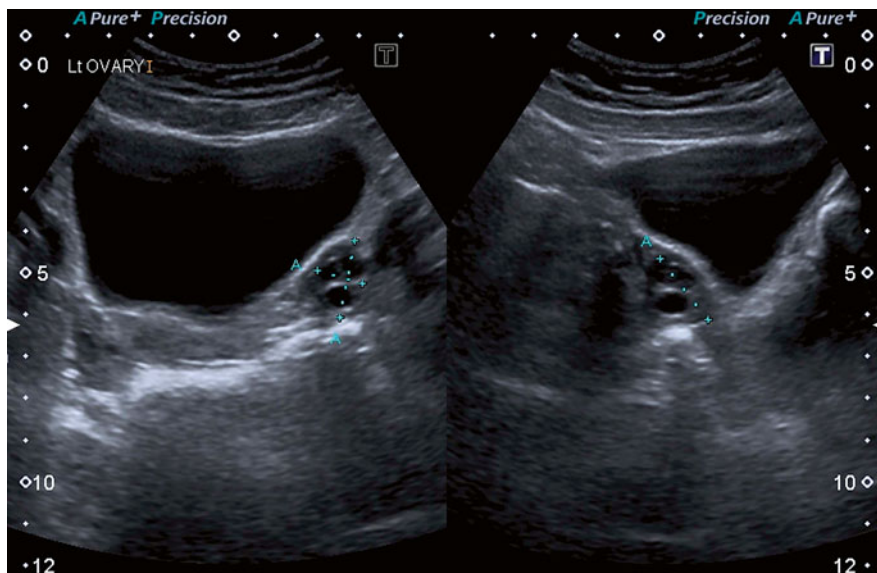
Measurement of the ovary, with a sonographic window provided by the full bladder
